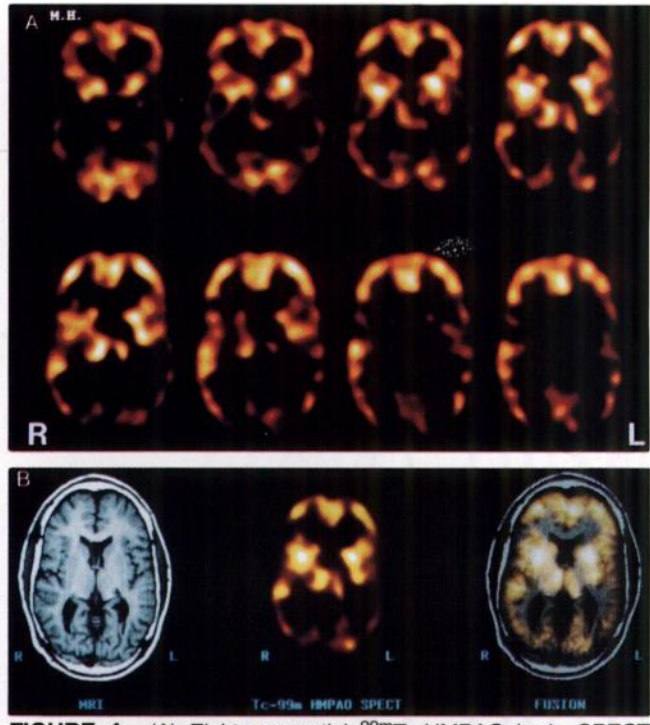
(A) Eight sequential ^{99m}Tc -HMPAO brain SPECT sections from Patient 4 show low tracer uptake by the posterior temporal and occipital lobes (CM + 5.5 cm, regions 4–8) and (CM + 7.5 cm, regions 3–9), respectively. (B) Coregistered MR, SPECT and fusion image at the level of the temporal and occipital lobes. The MRI section (left) is normal. The coregistered ^{99m}Tc -HMPAO brain SPECT section (middle) shows bilateral posterior temporal (left lower than right) and bilateral occipital diminution of tracer uptake with no corresponding anatomic abnormality, as demonstrated by the MRI-SPECT fusion image (right).
